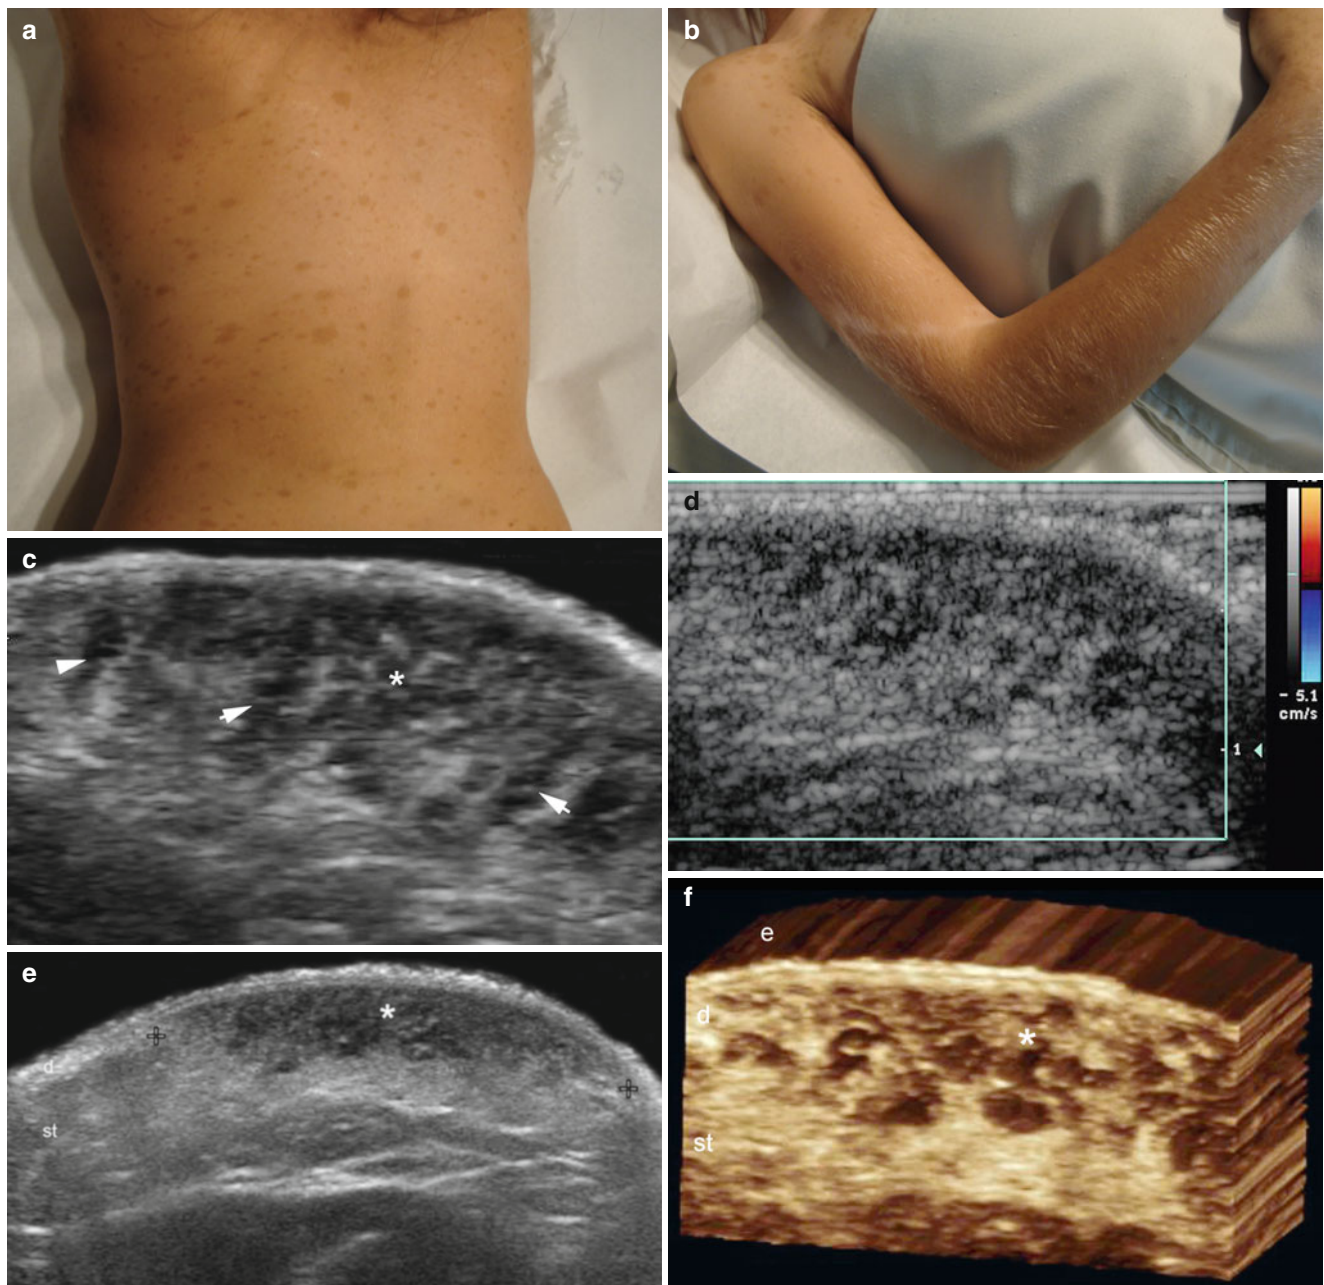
(a–f) Diffuse neurofibromatosis. (a, b) Clinical image shows multiple café-au-lait spots in the dorsal (a) and right upper extremity (b) regions. (c) Ultrasound image (gray scale, transverse view, right arm) demonstrates a hypoechoic and heterogeneous dermal and subcutaneous plaque-like structure (*) with several hypoechoic tortuous tracts (arrows). (d) Color Doppler ultrasound image (transverse view)
